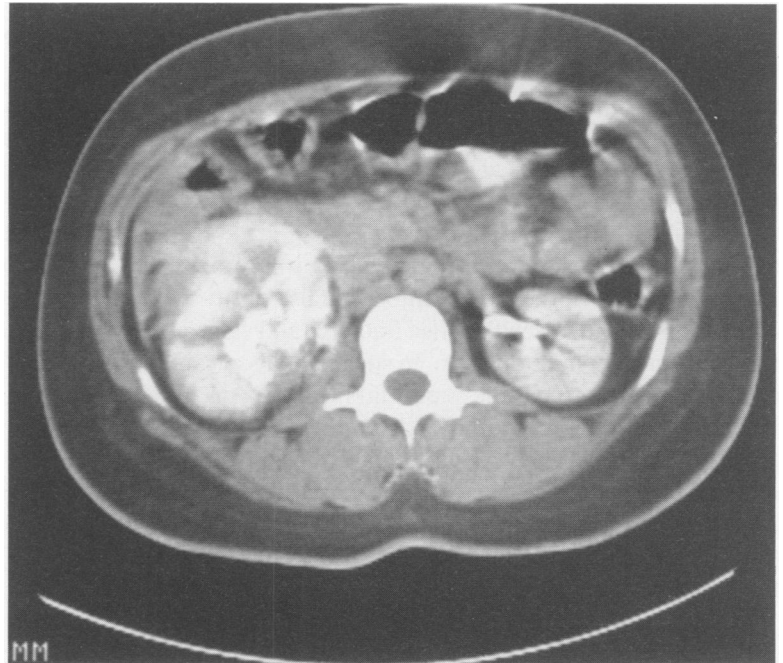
Transection of the body of the pancreas over the spine on CT (From Feliciano DV. *In* Schwartz SI, Ellis H, eds. *Maingot's Abdominal Operations*, 9th ed. East Norwalk, CT: Appleton & Lange, 1989; publication pending. Reprinted with permission.)
